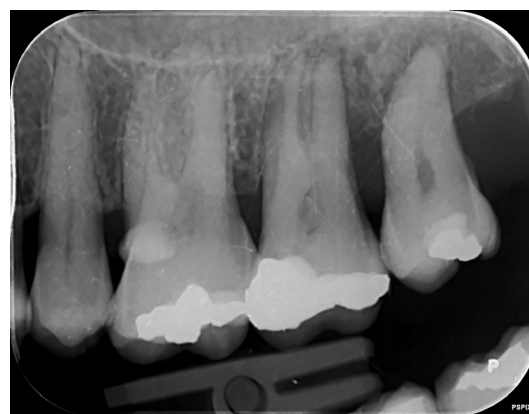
An intraoral periapical radiograph demonstrating severe periodontal disease affecting the upper left quadrant.
